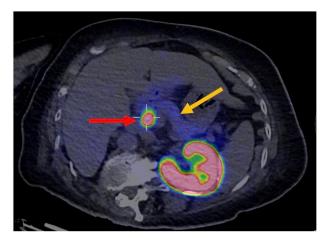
Positron-emission computed tomography (PET-CT) imaging was performed from the vertex of the skull to the upper thighs at 75 minutes after IV administration of 4.0 mCi ⁶⁸Gallium- DOTA-exendin-4. Dedicated upper abdominal images were acquired at approximately 150 minutes, demonstrating presence of a tracer-avid lesion, with maximum standar-dized uptake value (SUVmax) 80.1 at the head of pancreas, marked with a crosshair and red arrow. The rest of the pancreas demonstrates diffuse physiological tracer uptake as marked by yellow arrow. The patient's capillary blood glucose was monitored for the duration of the process due to documented risk of hypoglycemia in patients with insulinomas receiving exendin-4. No episodes of hypoglycemia were documented.
